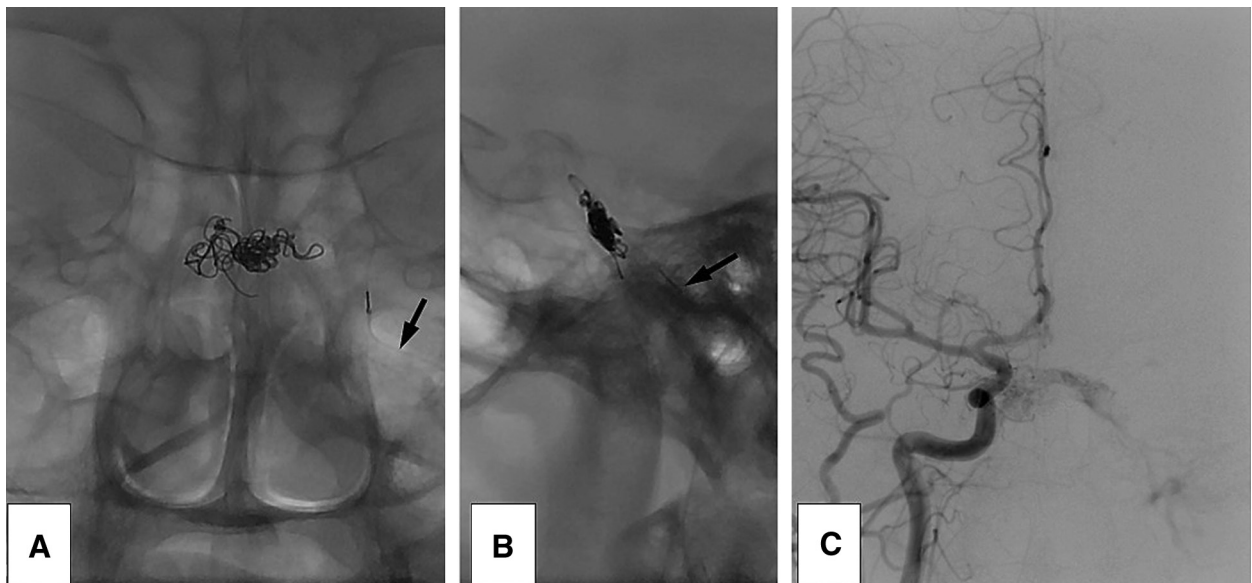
Plain skull radiography (A: antero-posterior view, B: lateral view) after the first session of TVE showing coils delivered by a microcatheter navigated through the left IPS (arrow). Right internal
